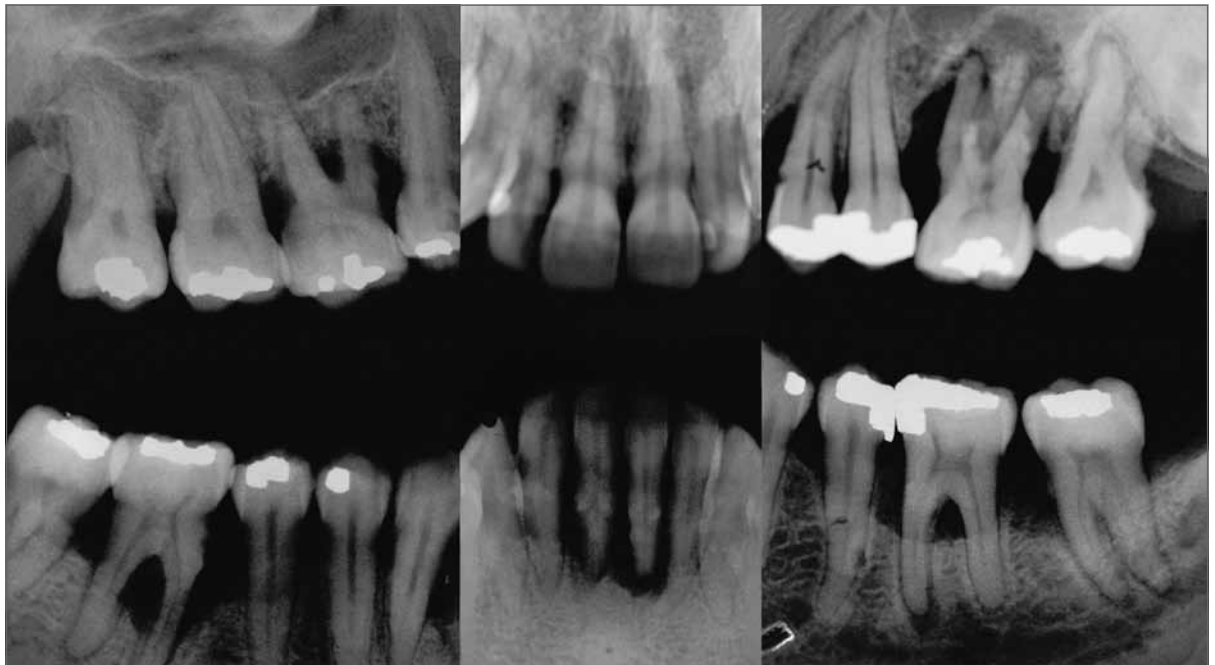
Full-mouth periapical radiograph examination showing generalized loss of bone support and loss of function for the mandibular central incisors and maxillary left first molar.
